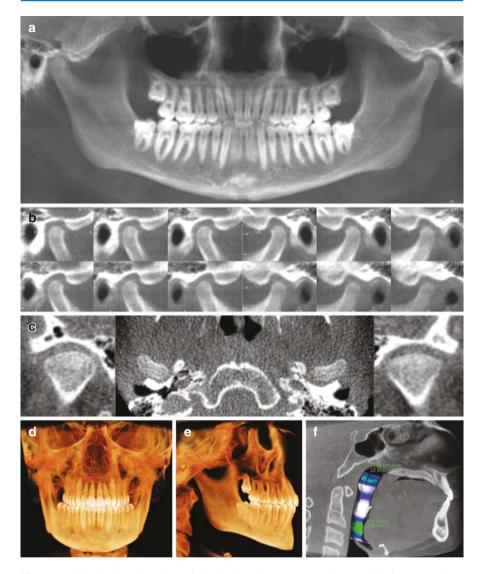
Following the orientation of the CBCT volume, cross sections specific for TMJ evaluation and diagnosis can be produced: (a) panoramic reformat, to give an overall view of the jaws; (b) sagittal oblique cross sections to show the anteroposterior morphology and spatial relationship of the TMJs; (c) coronal oblique and axial cross sections to show the mediolateral morphology and spatial relationship of the TMJs; (d) frontal 3D rendering to evaluate for asymmetry and transverse discrepancies which may be caused by the TMJ condition; (e) lateral 3D rendering to evaluate for asymmetry and sagittal changes to the jaws; and (f) airway analysis, which allows the evaluation of the effects of the TMJ condition on the oropharyngeal airway
